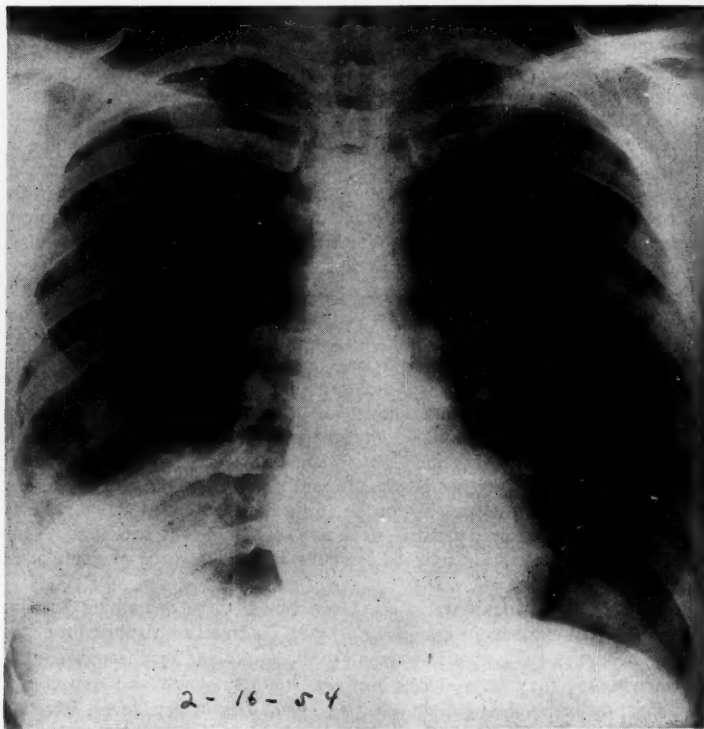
Chest x-ray on February 16, 1954, showing large homogeneous density at the right base.
